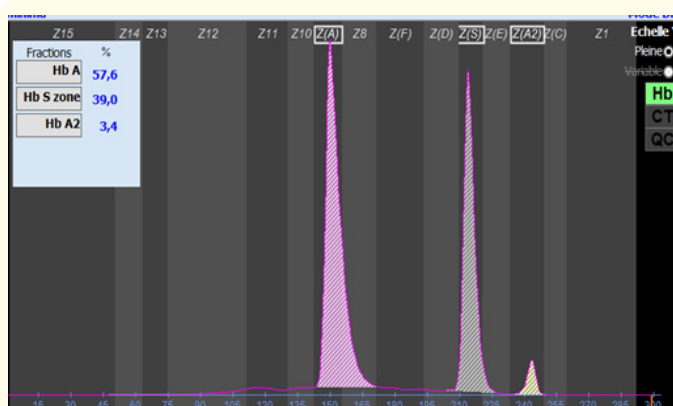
Electrophoretogram generated during screening for sickling disorder. Doppler imaging in the fundus of a patient with TA.
